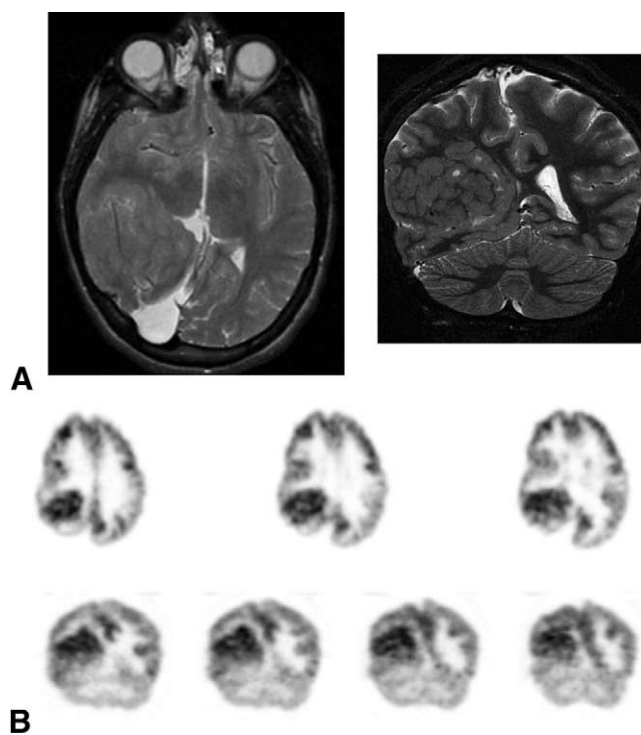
Complex partial seizures: A 14-year-old girl with an extensive migrational anomaly in the right temporal, parietal, and occipital lobes presents with medically refractory complex partial seizures. (A) Magnetic resonance imaging examination reveals a large right temporal, parietal occipital migrational anomaly. (B) Positron emission tomography with 2-deoxy-fluoroglucose (axial plane, upper row; coronal plane, lower row) study demonstrates increased radiotracer activity in the region of the migrational anomaly consistent with subclinical seizure activity. Posterior to this region is a photopenic area corresponding to the large cerebrospinal fluid space seen on magnetic resonance imaging.
